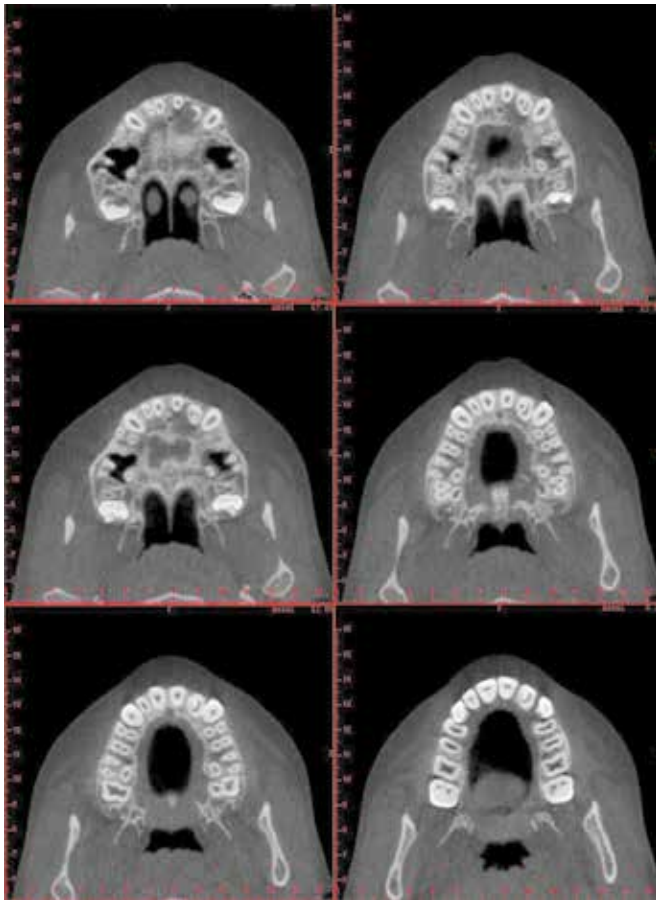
Cone-beam CT scan – coronal view.
